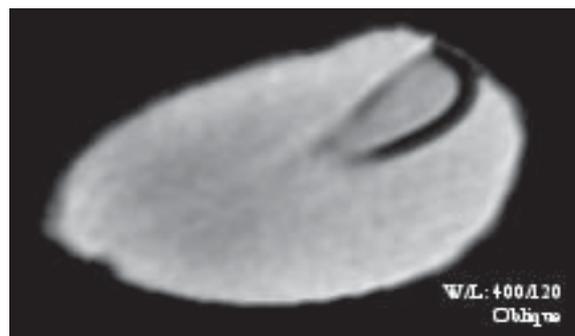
Ex vivo sagittal CT of a similar seed confirms the laminated nature, but demonstrates a peripherally located nidus that does not extend through the length of the seed.
